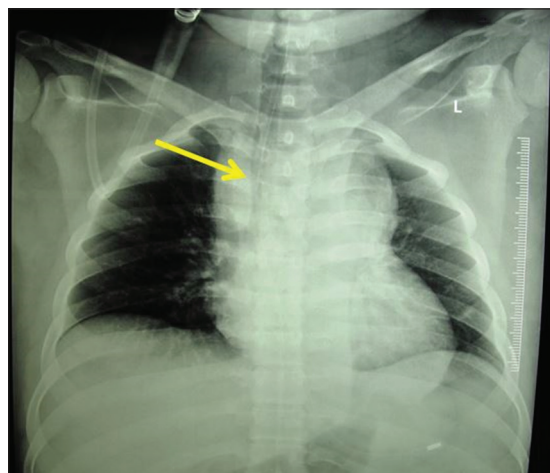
Chest X-ray anteroposterior view showing mediastinal widening with trachea deviated to right (arrow mark) and congestion of left lung
